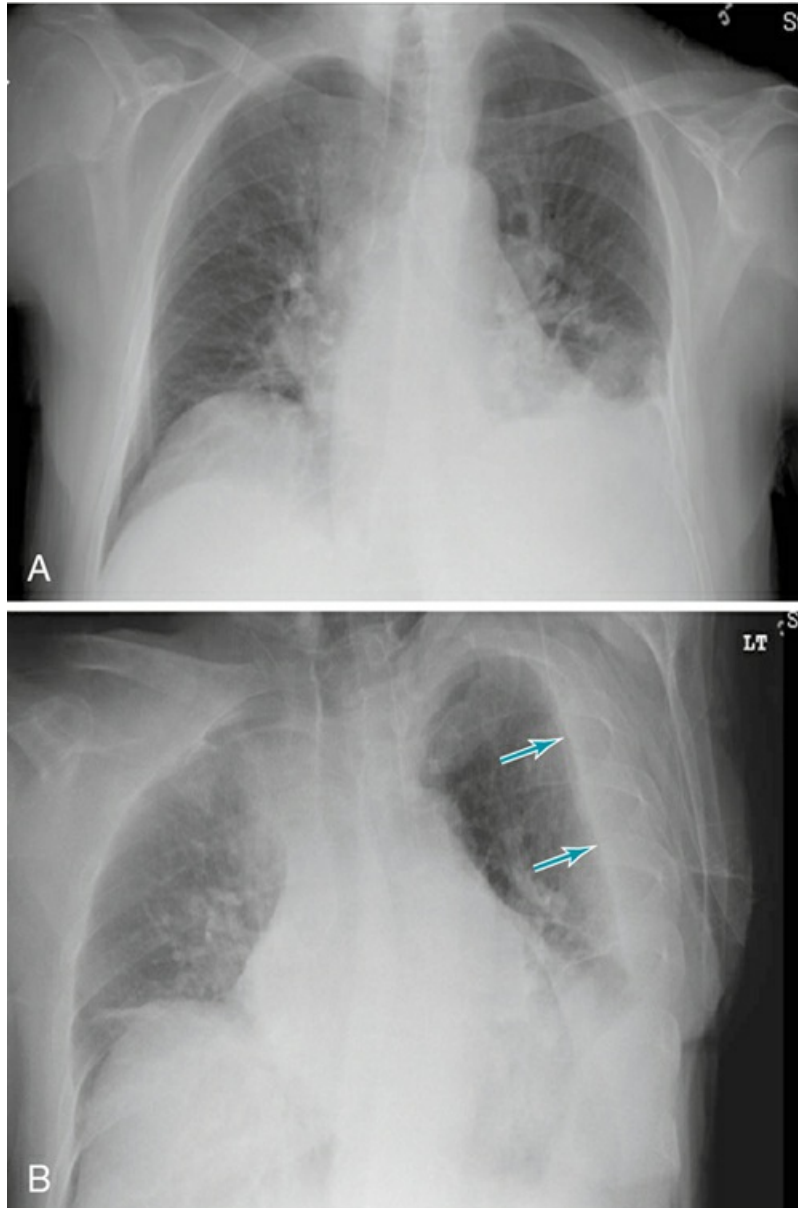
Posteroanterior (A) chest radiograph suggesting presence of left pleural effusion. Left lateral decubitus (B) chest radiograph of patient shown in A. With patient lying on left side, pleural fluid (*arrows*) flows freely to dependent part of pleural space adjacent to left lateral chest wall. Film is shown upright for convenience of comparison with A.
